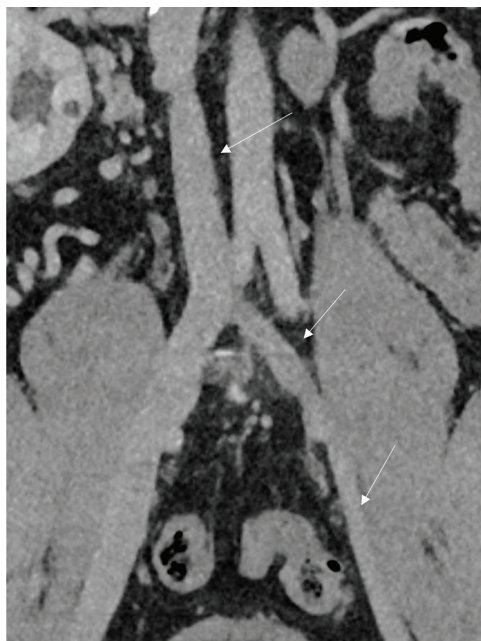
Computed tomography venography in a 5-month follow-up revealing resolution of prior thrombosis in the inferior vena cava and left iliac veins (white arrows).
